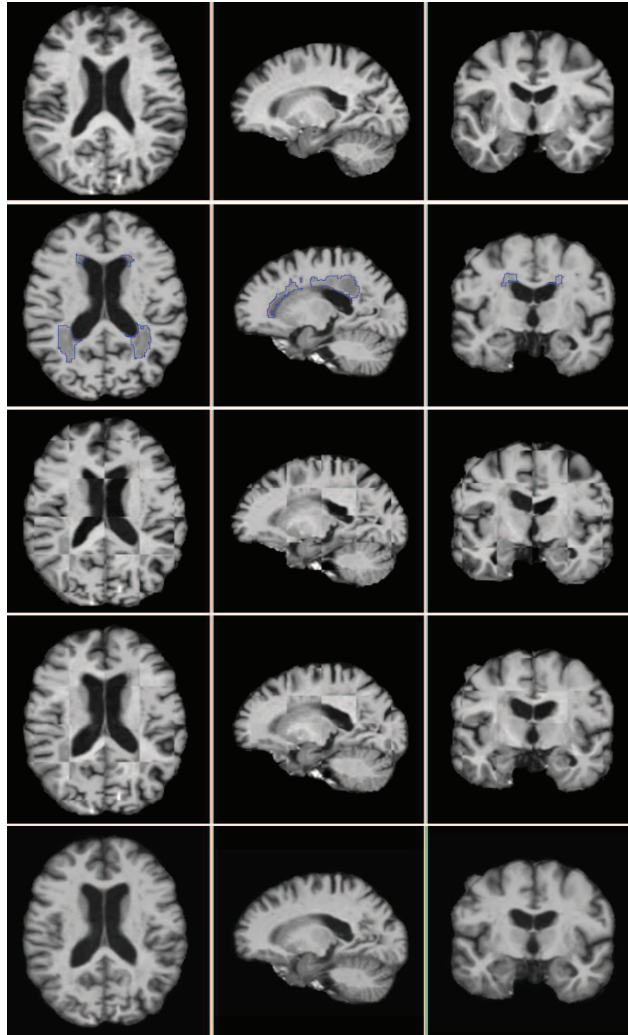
Register MRI of a healthy subject to that of a patient with lesion.
